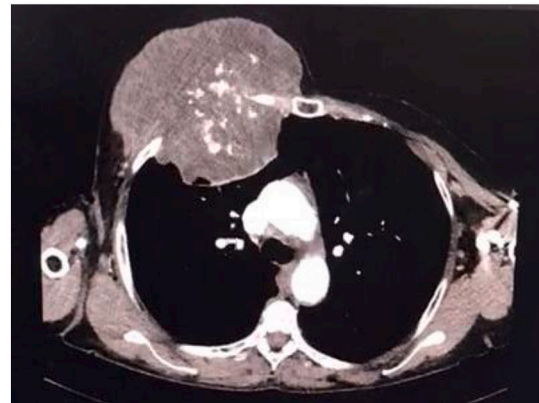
CT Scan showing a right sided large heterogeneous mass involving underlying soft tissues and destruction of the third rib.
